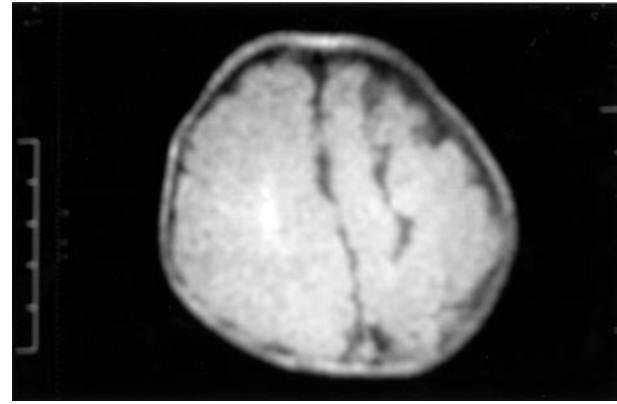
MRI Brain.Schizencephalic cleft left parietal lobe
